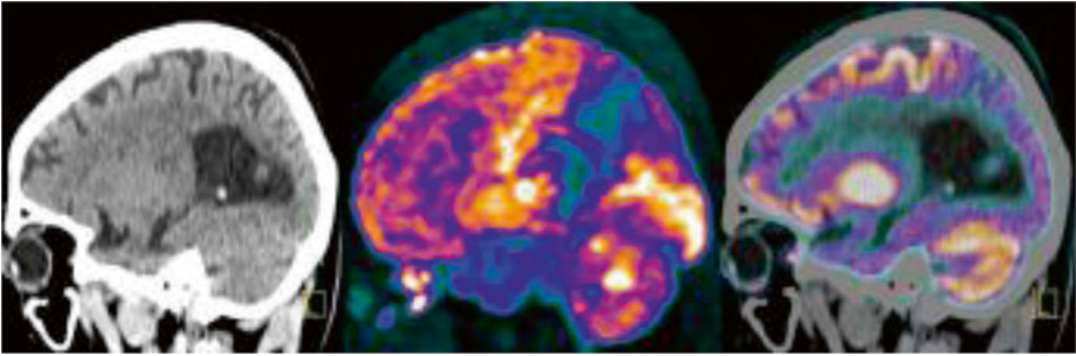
Sagittal plain CT (*left*), sagittal MIP (*middle*), and sagittal fused ^{18}F -FDG PET-CT image (*right*) of a case of Alzheimer's dementia, typical metabolic pattern with parietotemporal hypometabolism and relatively preserved uptake in both visual and sensorimotor cortices, basal ganglia, thalami, and cerebellar hemispheres
